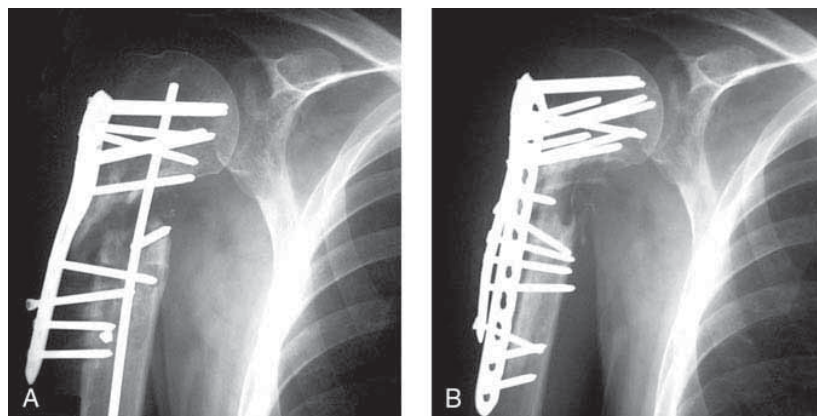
A, Shoulder radiograph demonstrating a nonunion of the proximal part of the humerus in a 35-year-old patient with diabetes who abused drugs and who had three previous operations. The locking plate lost purchase in the shaft fragment, and a retrograde Ender nail was used in an attempt to salvage the situation. The patient still had pain and clinically visible instability at the fracture site. B, Union was achieved with double locking plates, and an intramedullary fibular allograft was used to improve fixation in the shaft portion of the construct. Cancellous autogenous bone graft with bone morphogenetic protein was placed in the metaphyseal defect at the same time.
